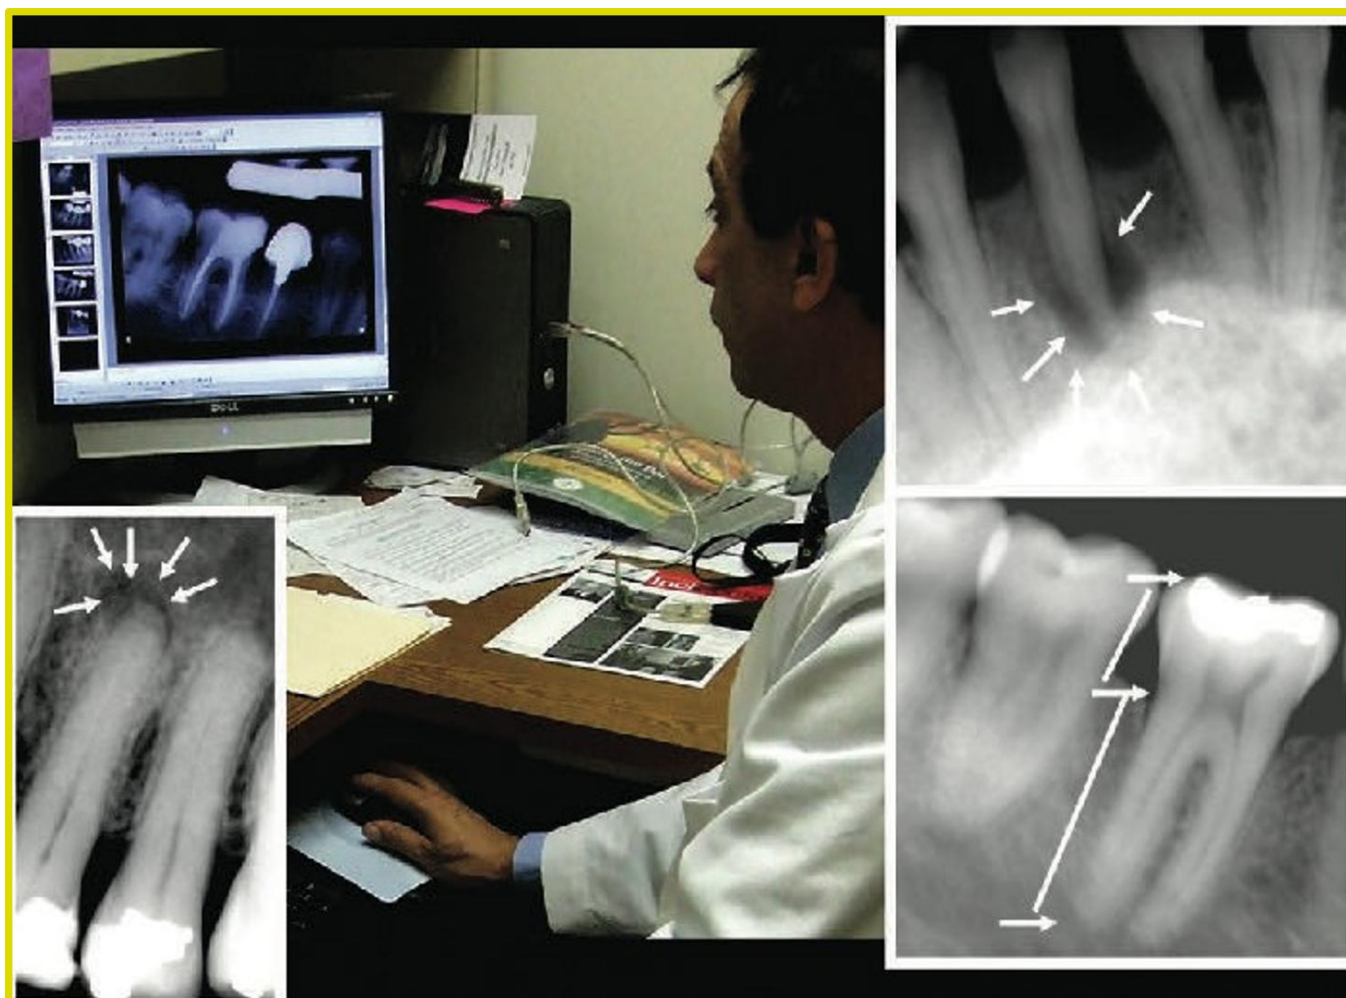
Endodontic evaluations using the RVG. These details clearly demonstrate the ability of sensors to demonstrate periapical lesions and tooth length.
